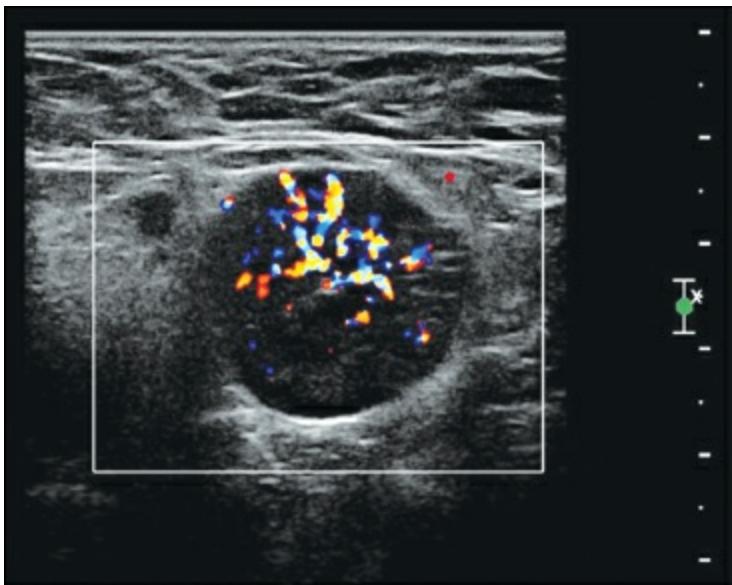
LYMPH NODES — AXILLARY. Exuberant blood supply to a benign, reactive AXILLARY LYMPH NODE is shown on this power Doppler image. Blood vessels are depicted entering the nodal hilus and arborizing into the cortex.
